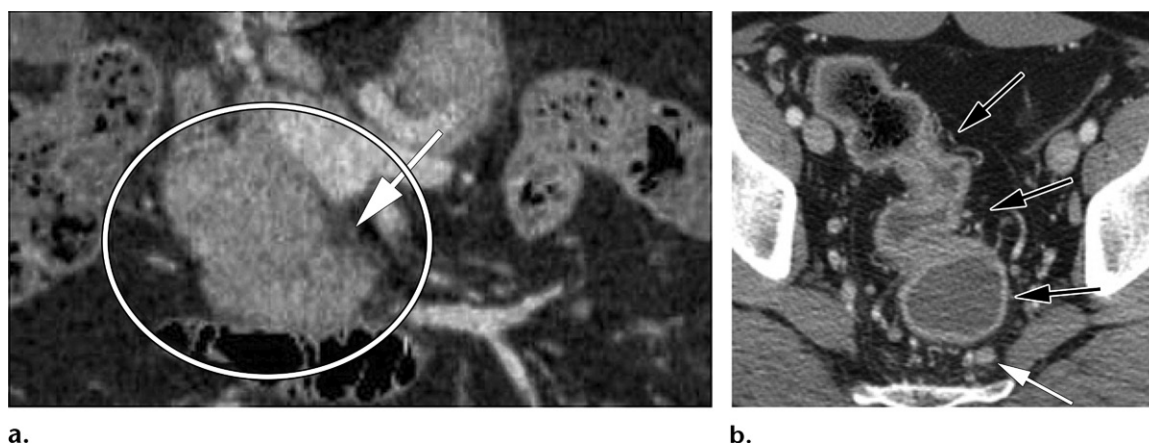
Type 2 AIP in a 40-year-old man. (a) Contrast-enhanced coronal CT image through the pancreatic head shows a focal pancreatic head mass (circle). Note the smooth outline, the loss of normal pancreatic lobulations, and the hypoattenuating fibrotic rim (arrow). (b) CT image through the sigmoid colon shows mural thickening and associated hyperenhancement. Associated pericolonic hyperemia and vascular congestion (black arrows) and lymphadenopathy (white arrow) are also seen. Colonoscopy and biopsy findings were consistent with ulcerative colitis. (Full DICOM image stacks are available online for Fig 7a and 7b.)
